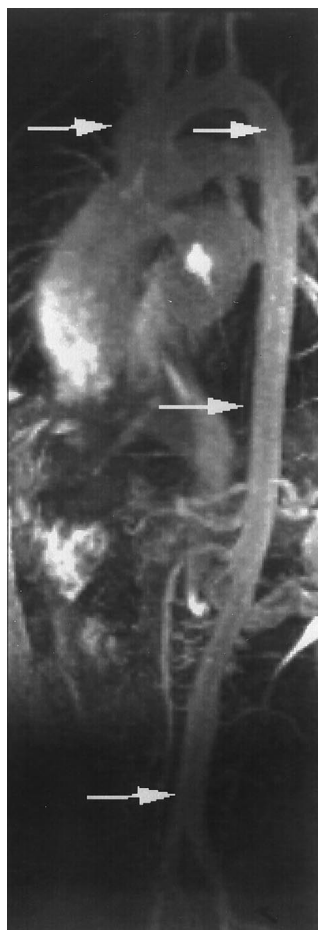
Three-dimensional MRI of the aorta. Arrows indicate the levels for distensibility measurement. Pulse wave velocity was measured along the entire aorta (from the first arrow at the ascending aorta to the arrow above the aortic bifurcation).
